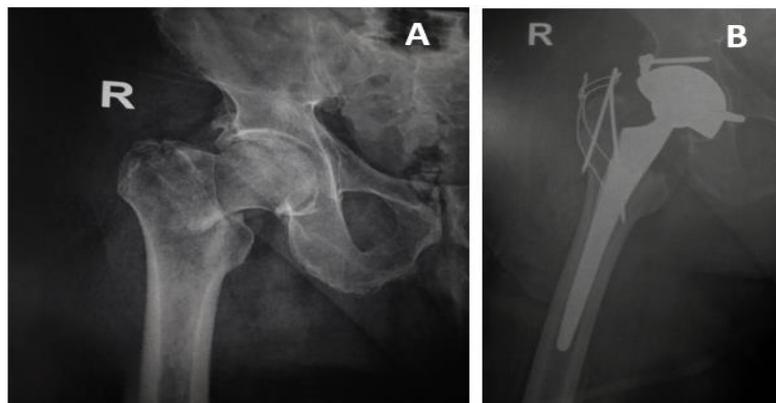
(3A): Pre-operative X-Ray of a 70 years Male, Hypertensive, Diabetic, Advanced Senile Dementia had Fracture neck of right Femur with Trochanteric Extension and Osteoarthritic hip (3B): Post-operative X-Ray of the patient after Cementless Dual Mobility THA with Trochanteric Reconstruction by Tension Band technique
